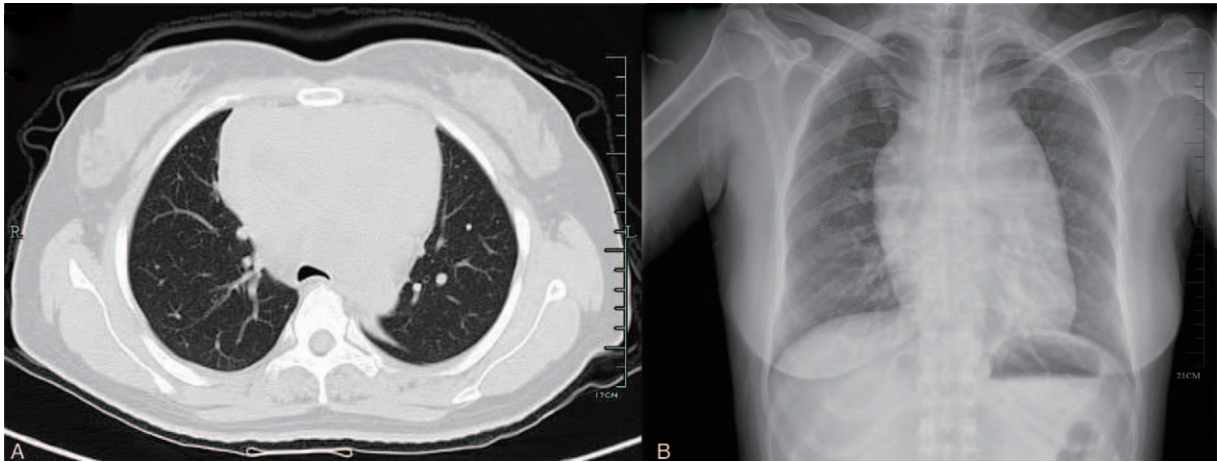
Chest computed tomography (A) and X-ray (B) of the patient before the operation. There was a massive mass in the anterior mediastinum.
